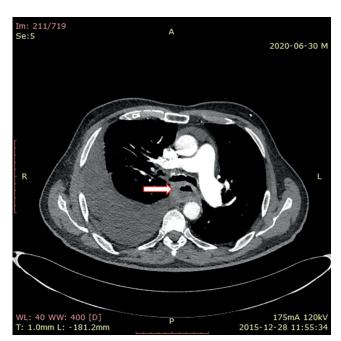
Hydro-computed tomography (CT) image of the esophagus in axial reconstruction in a patient with a T4 stage of esophageal cancer and a large esophageal diverticulum filled with content located supravascularly on the right side. The tumor causes a concentric thickening of the esophageal wall at the level of the tracheal bifurcation with proximal dilatation of the esophagus, with a broad contact with the thoracic aorta and the Th8 vertebra, and with infiltration of the right intermediate bronchus (causing atelectasis in the right lower lobe), the pericardium and the outflow of the pulmonary veins
